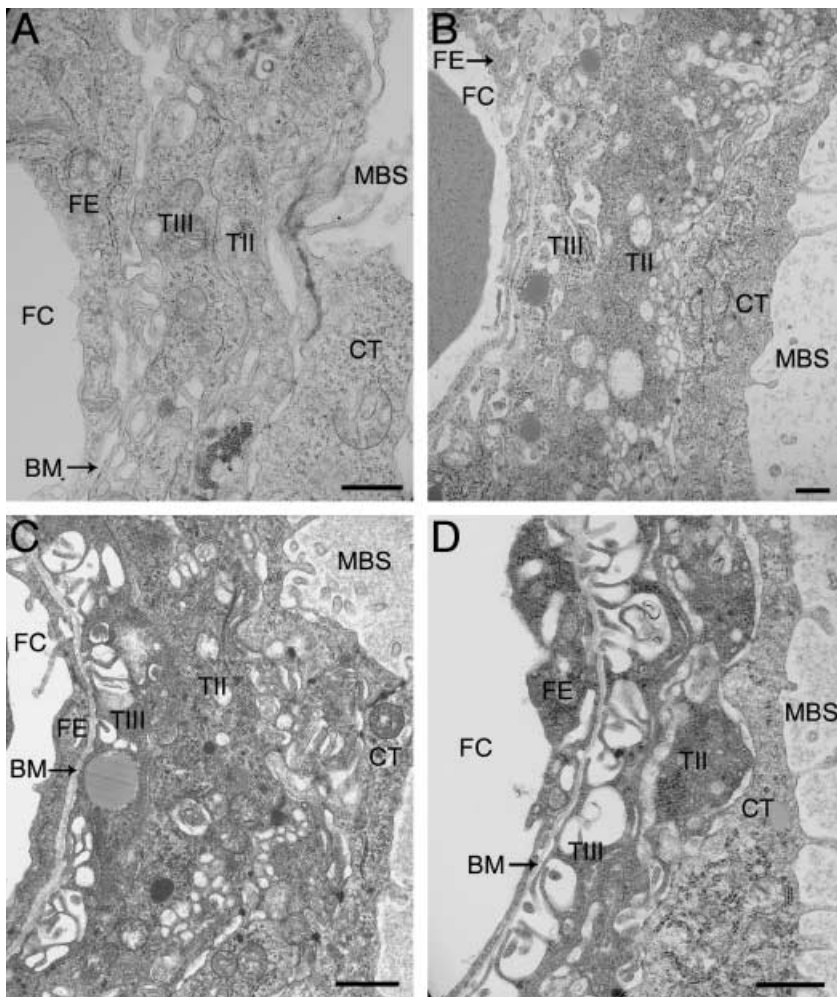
Development of the labyrinthine interhaemal membrane with gestational age. (A) E12.5 interhaemal membrane showing maternal blood space (MBS) surrounded by cytotrophoblast (CT), directly apposed to the first syncytial trophoblast layer (TII), then the second syncytial trophoblast layer followed by basement membrane (BM), separating from the fetal endothelium (FE) that surrounds the fetal capillary (FC). (B) E14.5 interhaemal membrane. (C) E16.5 interhaemal membrane. (D) E18.5 interhaemal membrane. Scale bar = $1 \mu\text{m}$.
